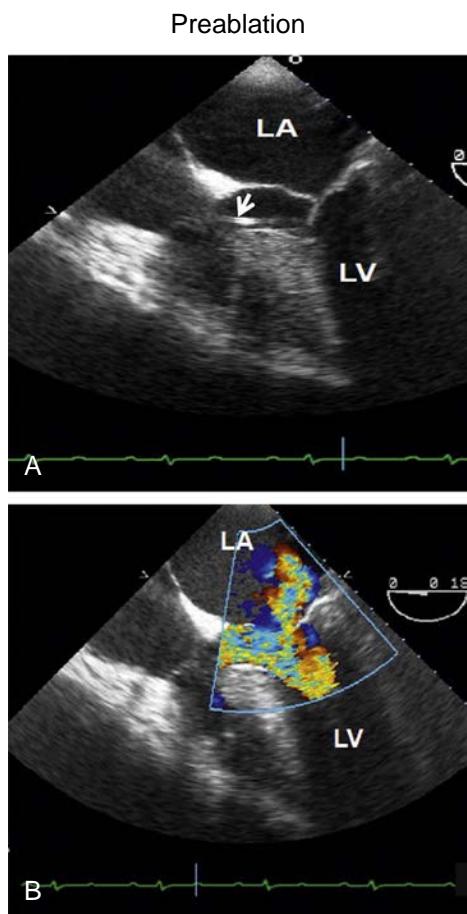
Transesophageal echocardiographic images. (A) Two-dimensional image shows a narrowed left ventricular outflow tract with systolic anterior motion (arrow). (B) Color Doppler image shows high-velocity signals in mosaic color; eccentric mitral regurgitation is directed posterolaterally. LA, Left atrium; LV, left ventricle. (From Naguch SF, Bierig M, Budoff MJ, et al. American Society of Echocardiography clinical recommendations for multimodality cardiovascular imaging of patients with hypertrophic cardiomyopathy. *J Am Soc Echocardiogr*. 2011;24:473–498.)
